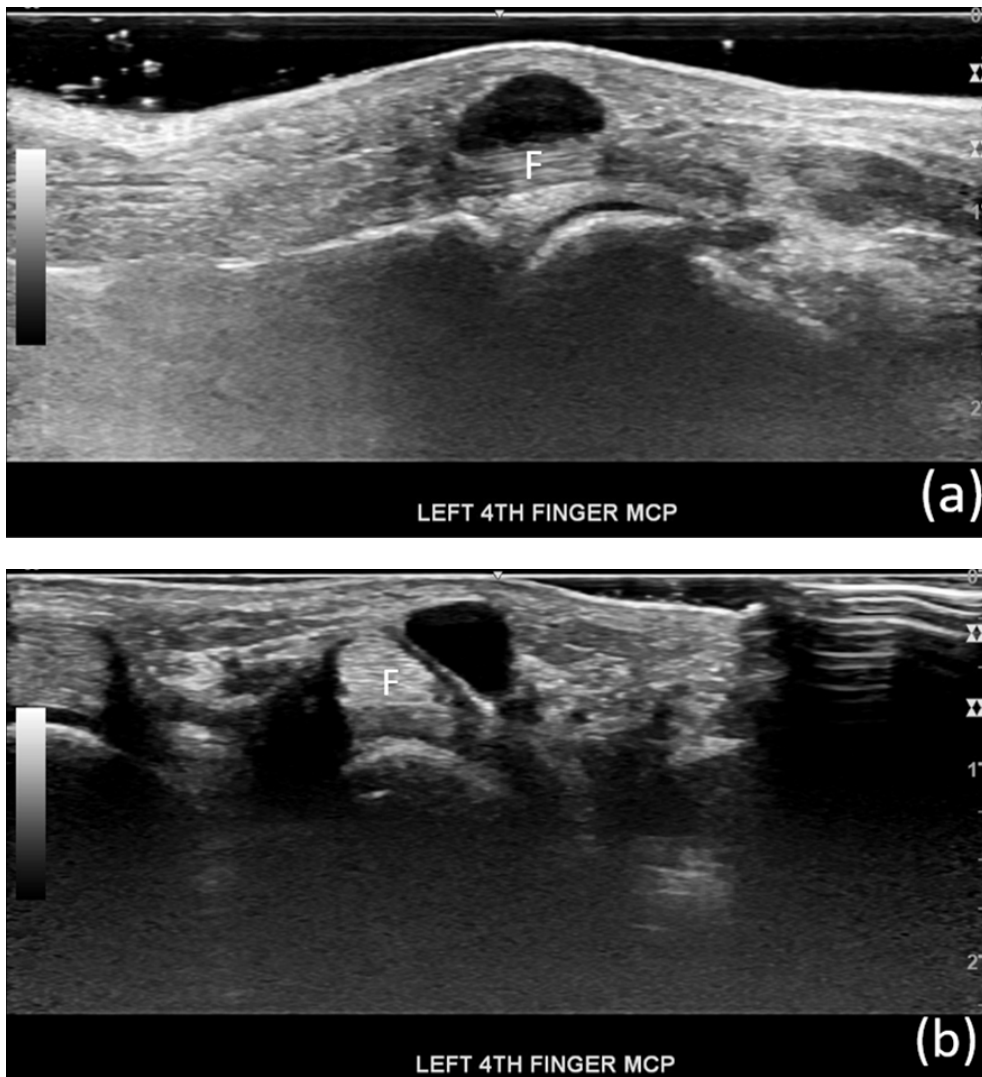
Musculoskeletal ultrasound of the left fourth finger at the MCP joint in (a) the sagittal view and (b) the transverse view. F, flexor digitorum tendons.
